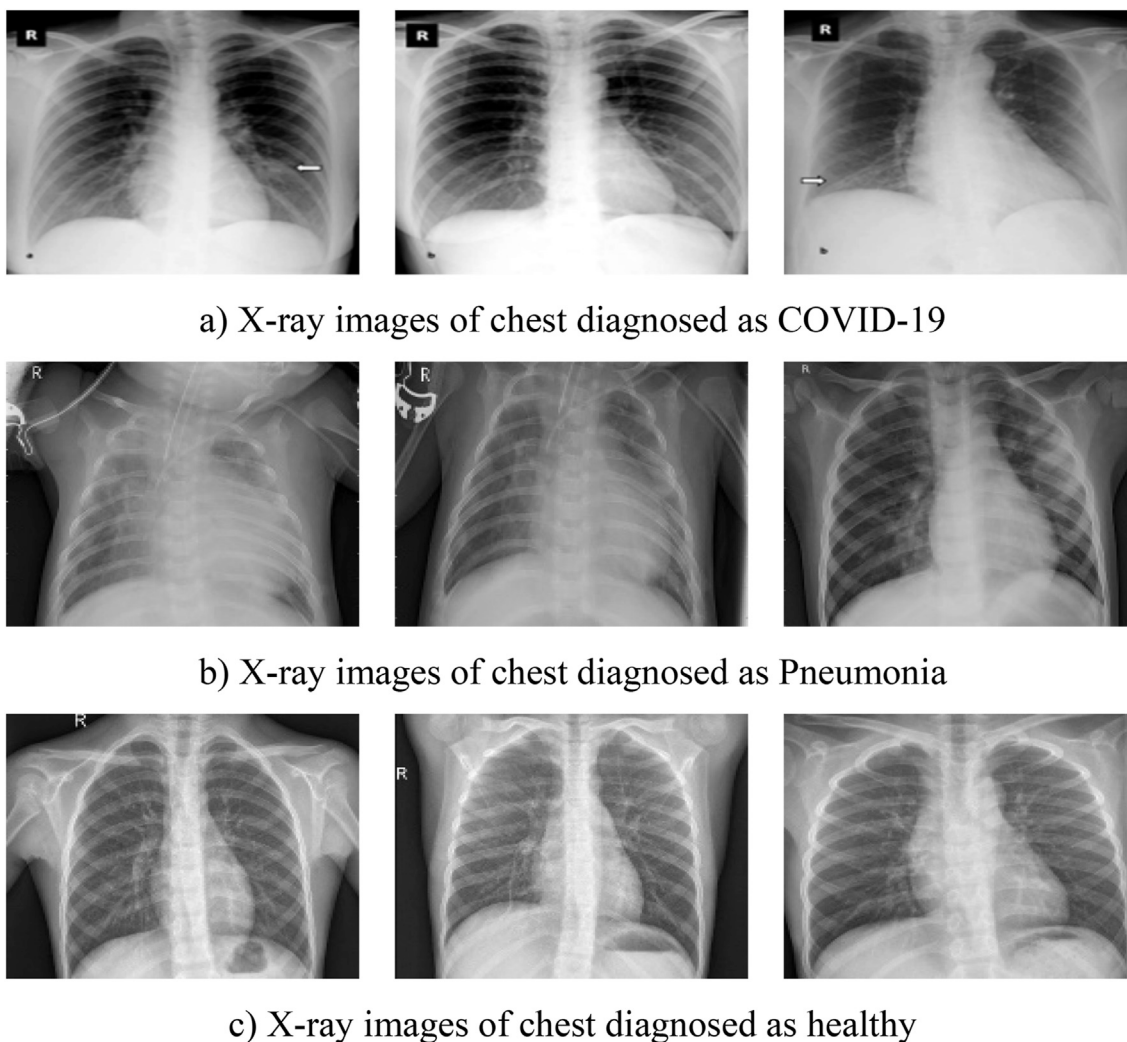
Representation of chest x-ray images.
